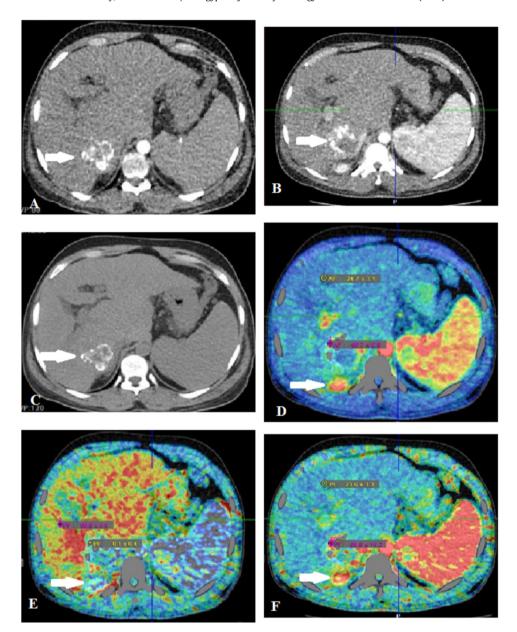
Triphasic CT examination: (A), (B) and (C) are the arterial, venous and delayed phases respectively showing segment VII focal lesion with dense lipidiol material and no definite enhancement pattern in arterial, venous or delayed phases (white arrow). CTP shows peripheral active tumoral tissue (white arrow) seen with high AF in (D), low PF (E) and high hepatic PI in (F) in comparison to the surrounding hepatic tissue. Diagnosis: residual/recurrent right hepatic lobe segment VII HCC after TACE.
